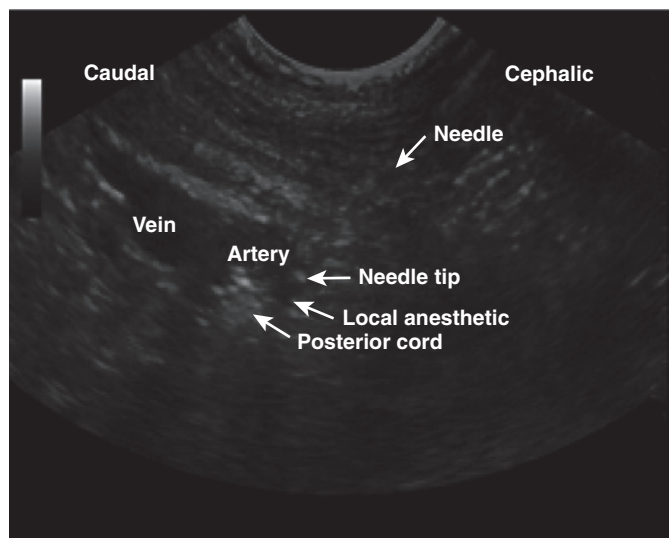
Ultrasound-guided infraclavicular nerve block; note the perivascular spread of local anesthetic.
